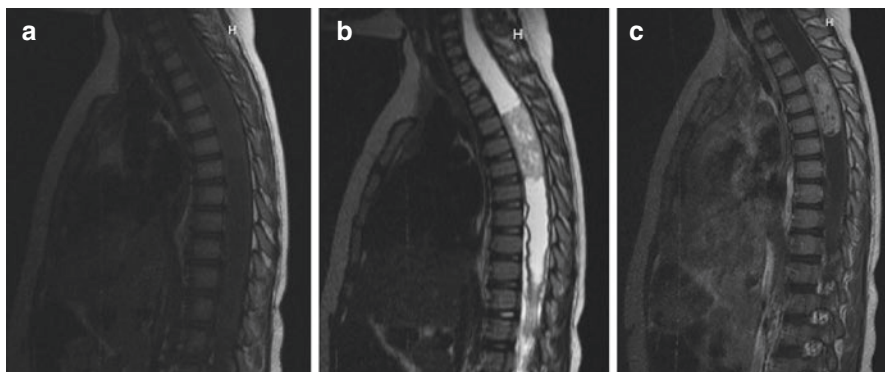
A 3-year-old female presented with progressive weakness, back pain, and torticollis. Sagittal T1 (a), T2 (b), and Gadolinium-enhanced T1 (c) magnetic resonance images were performed. These demonstrate a T4–6 enhancing intramedullary spinal cord tumor with associated holocord syringomyelia. A T3–7 laminoplasty was performed with a dorsal median myelotomy to resect the tumor. The final pathological analysis was consistent with Grade I pilocytic astrocytoma
